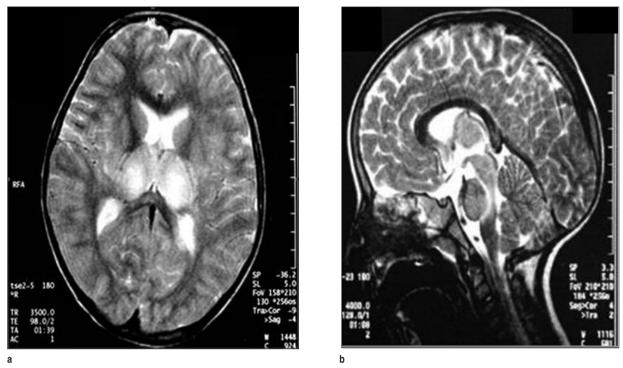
Axial and sagittal T2 weighted MR images demonstrates pathological hyperintense lesions in upper brainstem, thalamus, splenium of corpus callosum with edema effect on the third ventricle and perimesencephalic cistern.
